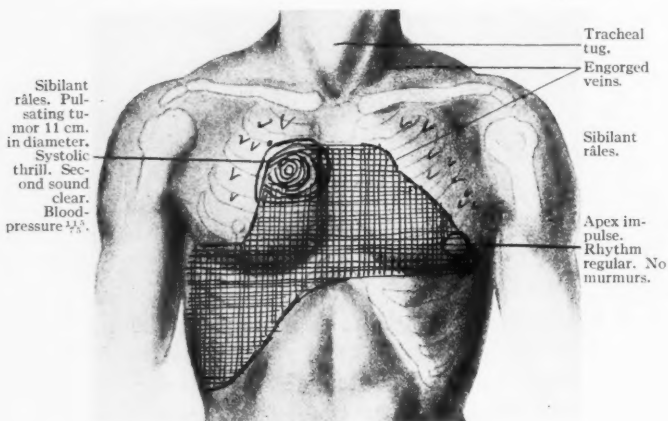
Physical signs anteriorly. Urine: slight trace of albumin, no casts. P. 80–100. Temp. 98°–100° F. Leukocytes 9520. Wassermann positive. x-Ray: aneurysm of aortic arch, large, and situated rather anteriorly.
